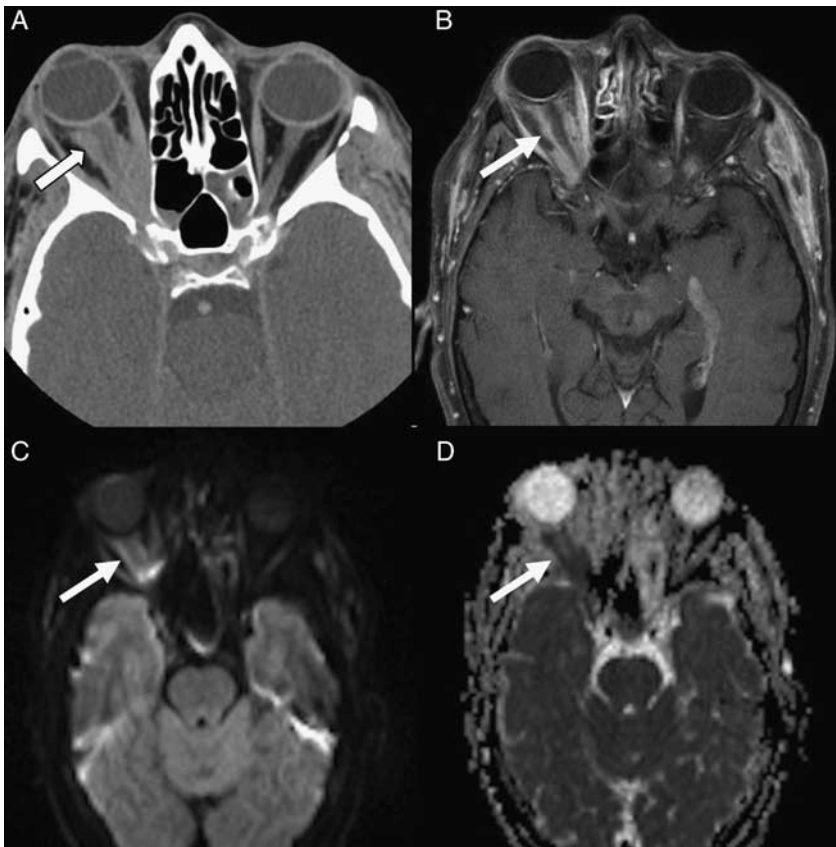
68-year-old woman with a history of marginal zone lymphoma presented with progressive right eye proptosis. Axial contrast-enhanced computed tomography demonstrates enhancing soft tissue extending from the orbital apex in the intraconal space along the optic nerve (A, white arrow). Axial T1-weighted postcontrast fat-saturated magnetic resonance imaging demonstrates the same infiltrative intraconal hyperenhancing mass (B, white arrow). The mass demonstrates high signal on diffusion weighted imaging (C, white arrow) and low signal on apparent diffusion coefficient (D, white arrow), consistent with restricted diffusion and characteristic of lymphoma.
